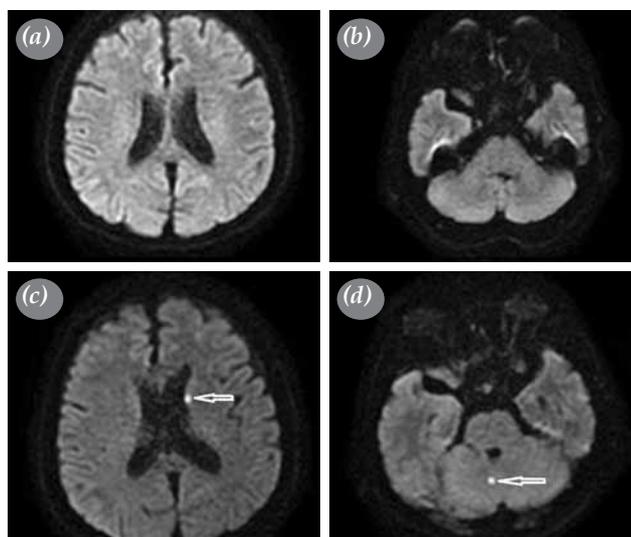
Diffusion-weighted magnetic resonance imaging one week before (a, b) and 2-4 days after (c, d) coronary artery bypass grafting. While there is no acute ischemic lesion preoperatively, there are multiple hyperintense foci at different cerebral anatomic locations postoperatively. Small new lesions (arrows) appear in the left caudate nucleus head and right temporal lobe white matter postoperatively.
